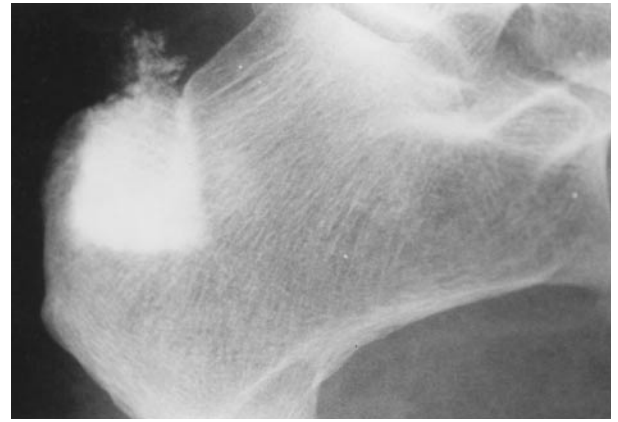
Lateral postoperative radiograph (18 months) after packing of calcaneal bone graft donor site with hydroxyapatite. Note the superior extrusion.
